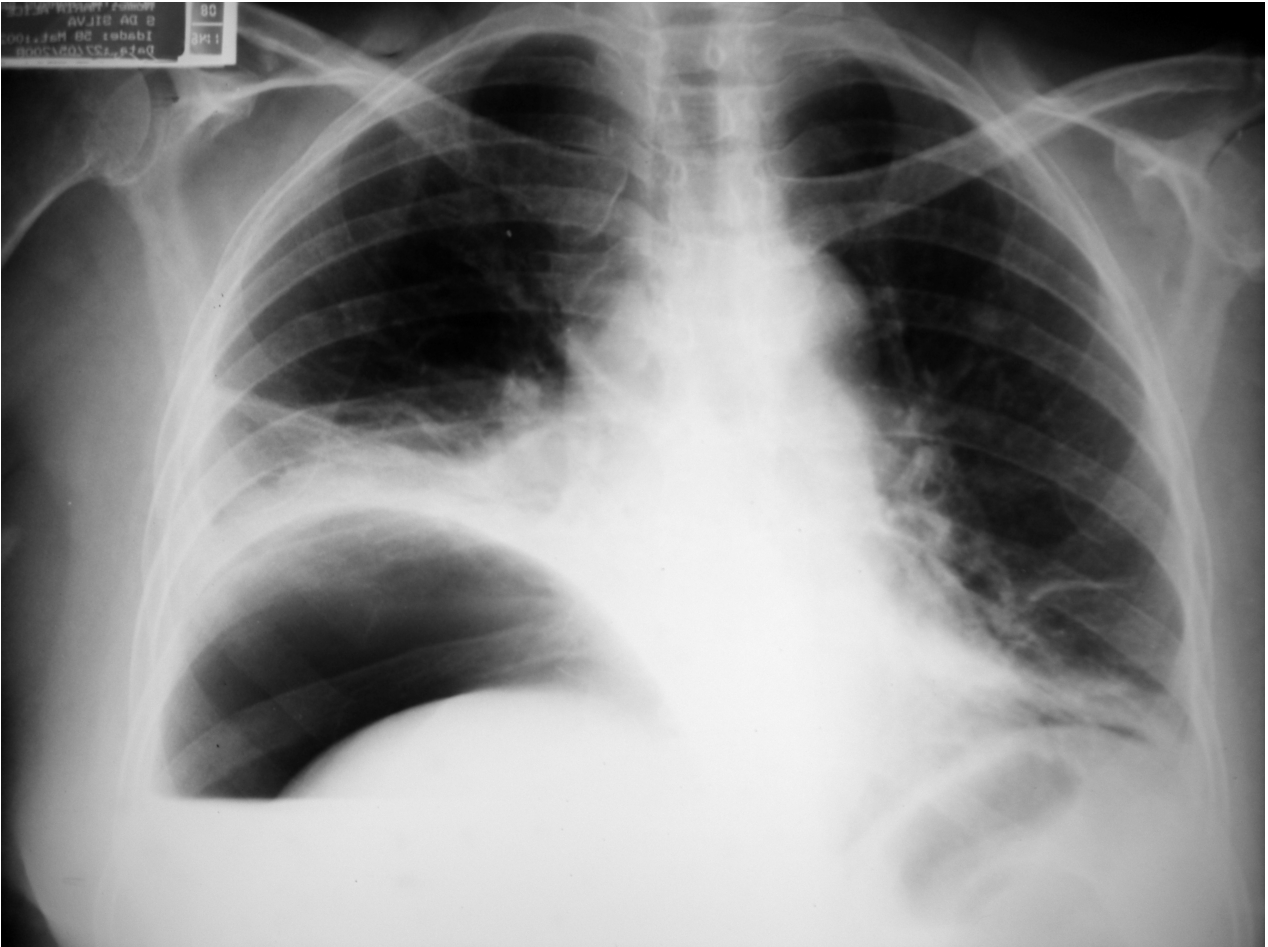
Plain chest radiography showing a large amount of free air beneath the right leaf of the diaphragm.
